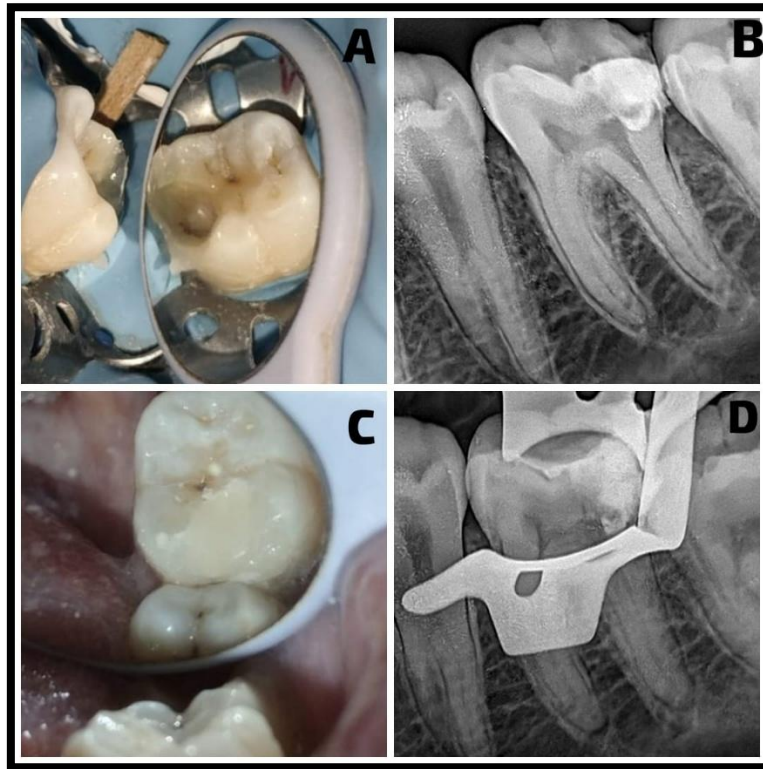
A: Pre operative clinical image B: Pre - optative radiographic image C: Clinical image of caries excavation and pulp exposure D: Radiographic image of caries excavation
